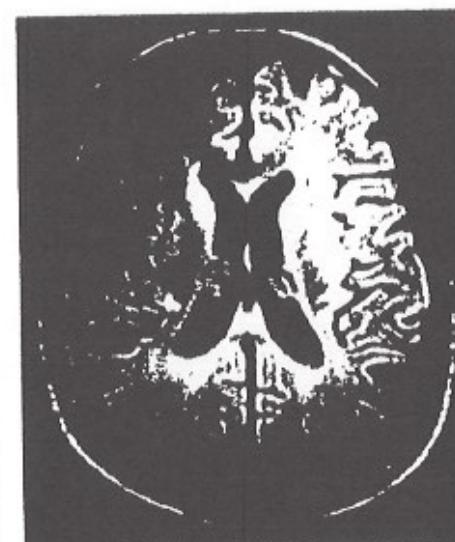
T₁-weighted axial magnetic resonance imaging scan of patient 3 shows multiple areas of periventricular demyelination (TR = 900; TE = 20).
